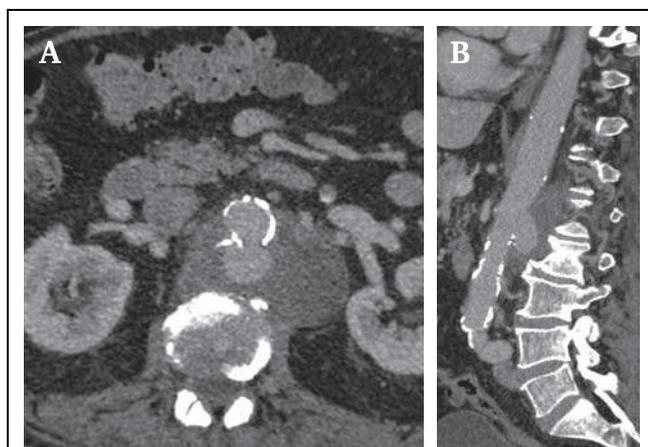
Paravisceral mycotic aneurysm. (A) Axial computed tomography angiography (CTA) image demonstrating asymmetrical posterior extension of the aneurysm, with inflammatory involvement of the back aortic wall. (B) Sagittal reconstruction showing pronounced posterior protrusion of the paravisceral aneurysm, consistent with mycotic degeneration and localised wall destruction (artist and copyright Carlota F. Prendes, Uppsala, Sweden).
